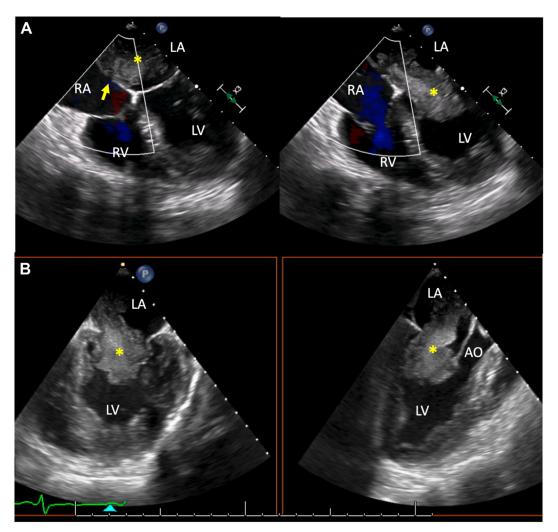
(A) Intraoperative two-dimensional TEE, midesophageal 4-chamber (0°) view, rightward rotated in systole (left) and diastole (right) with color-flow Doppler, demonstrates a large, mobile mass (*) that is likely originating from the interatrial septum (arrow) and protruding across the mitral inflow in diastole. (B) Mitral commissural (55°) view (left) and long-axis (145°) view (right) demonstrates a large hypermobile, heterogeneous mass protruding through the mitral valve during diastole. AO: Aortic valve; LV, left ventricle; RV, right ventricle.
